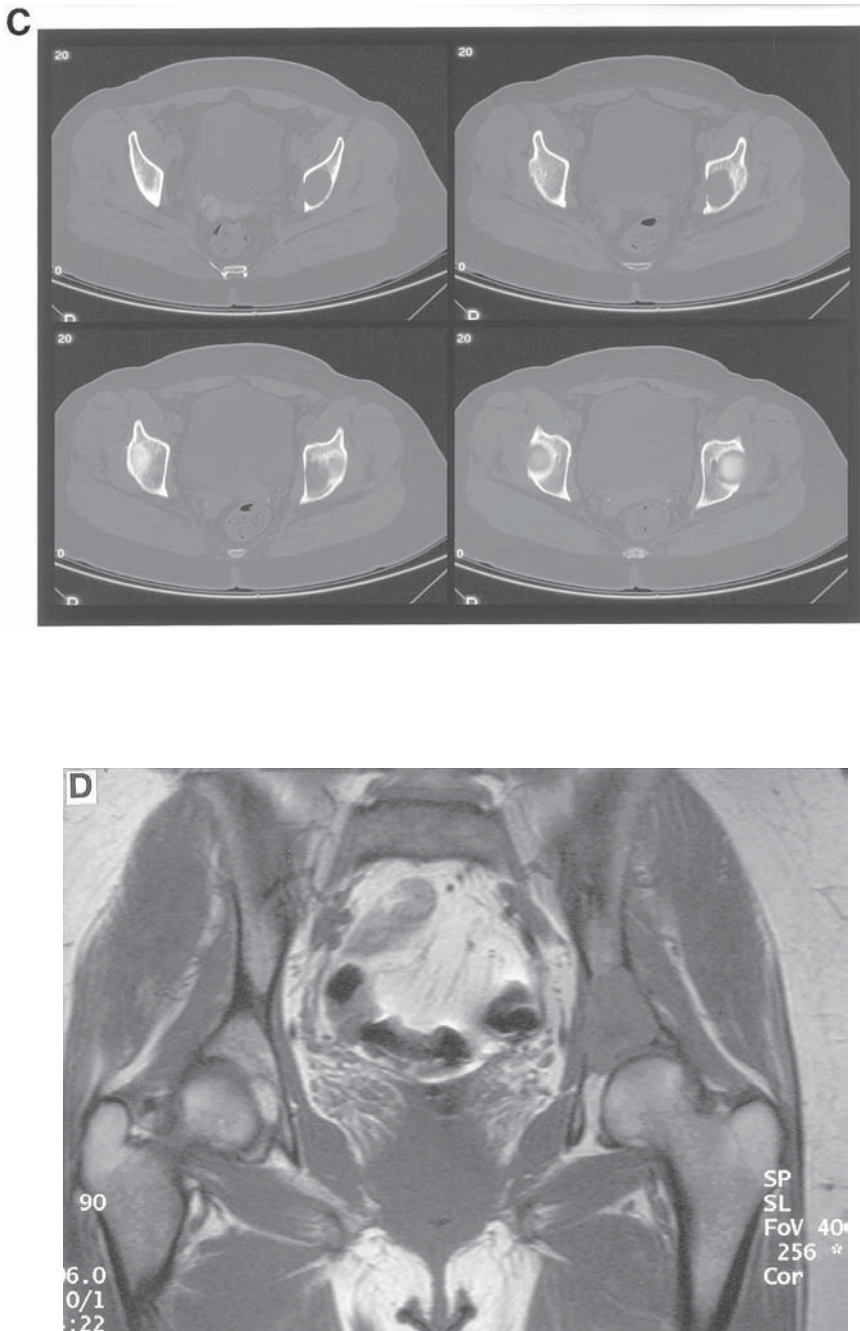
(Continued). (C) CT scan shows involvement into the acetabular fovea. (D) MRI shows the soft-tissue mass and truly defines the intraosseous extent of the metastatic lesion.
